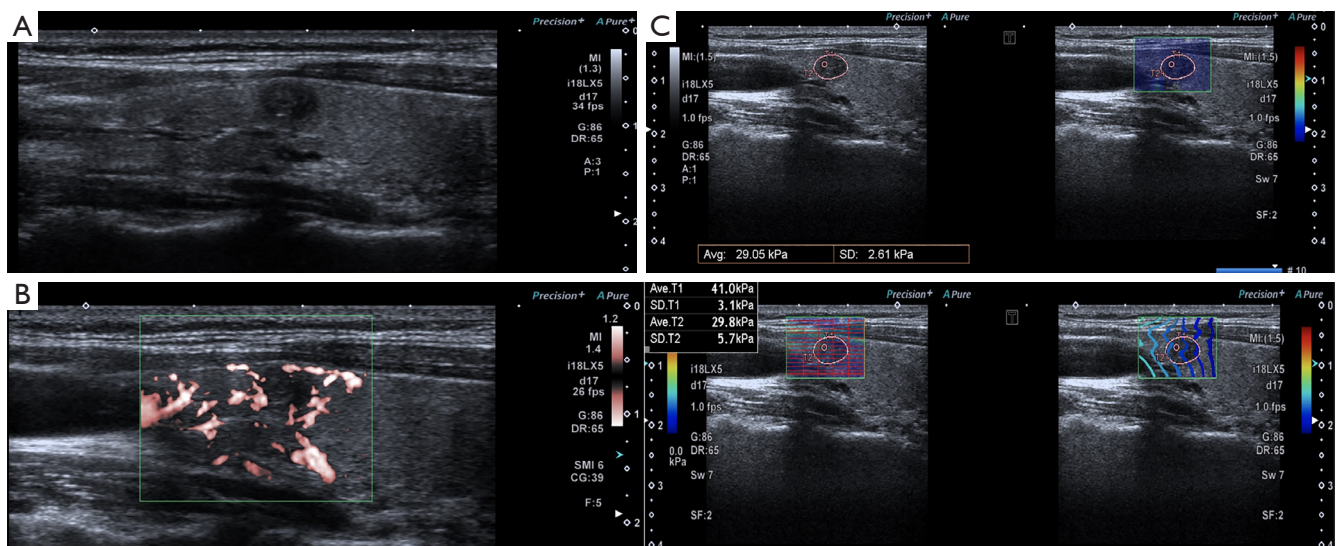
US, SMI, and SWE images of thyroid nodules in the right lobe. (A) The US feature of the thyroid nodule. (B) Penetrating vascularity can be seen in SMI, and the blood flow distribution is type IV. (C) The SWE value of the thyroid nodule is 29.8 kpa. SD, standard deviation; US, conventional ultrasound; SMI, superb microvascular imaging; SWE, shear wave elastography.
